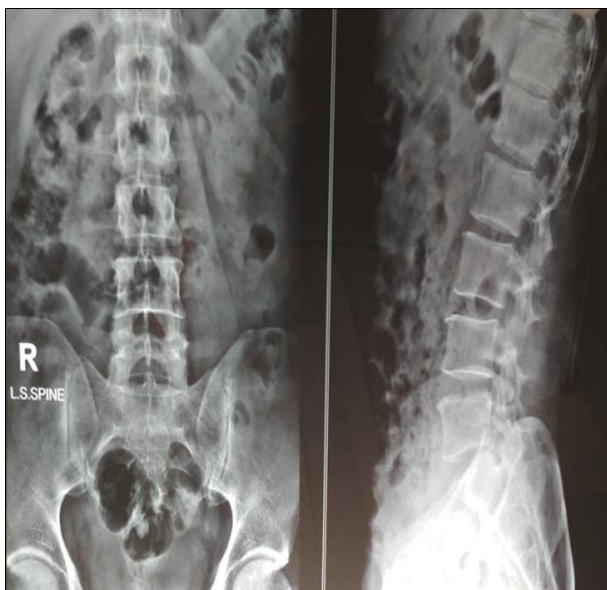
X-ray LS spine antero-posterior and lateral views with decreased L5-S1 disc space
